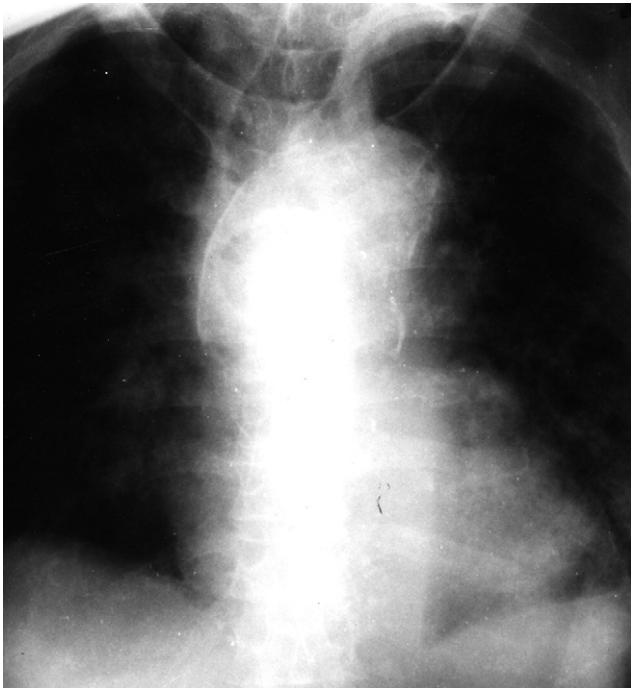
Radiograph of chest in patient described in Figure 5. Linear calcific deposits present in tubular portion of ascending aorta. Calcific deposits present only in intima of aorta.
